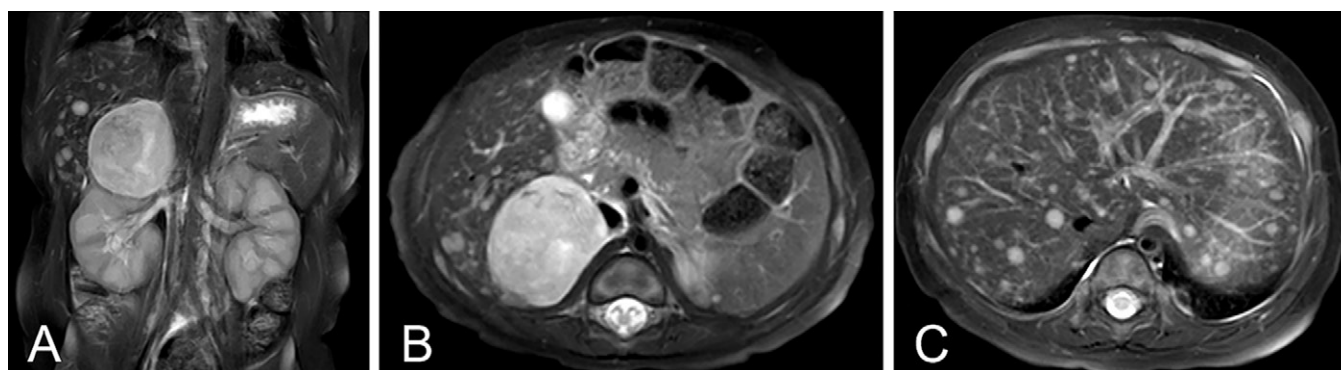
A case of abdominal neuroblastoma in a 1-month-old male infant. (A) Coronal and (B) axial T2-weighted images indicate that the primary lesion is confined to the right adrenal gland without image-defined risk factors. (C) Axial T2-weighted image shows that metastatic lesions are confined to the liver. This case is classified as MS stage.
